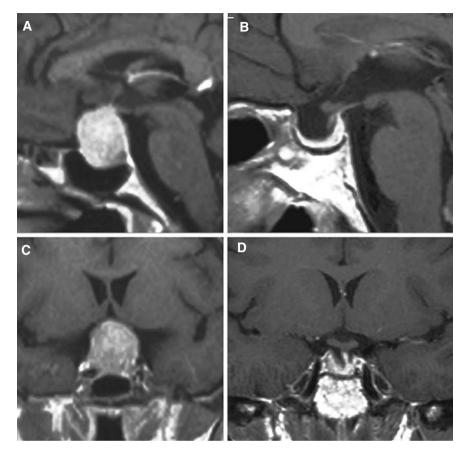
Pre-operative (A, C) and post-operative (B, D) contrast-enhanced sellar MRI of a case of intra-suprasellar pituitary macroadenoma
